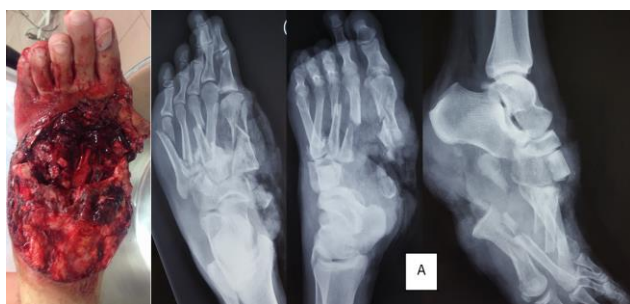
Initial plain radiograph of the left foot.
